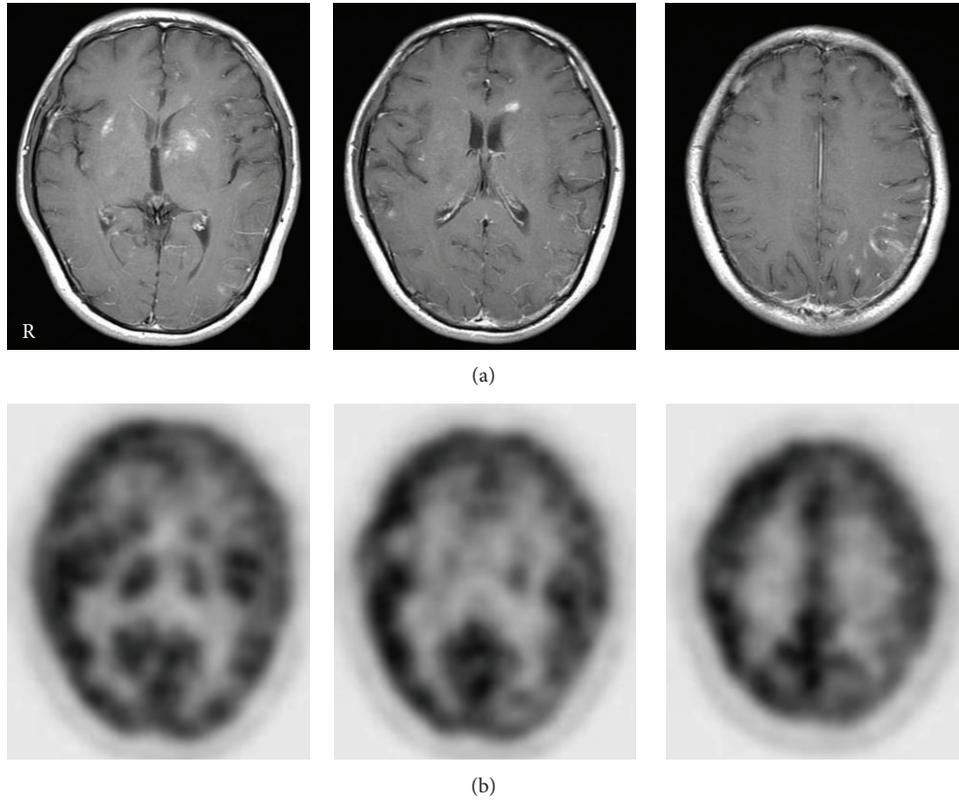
Contrast-enhanced T1-weighted MR (a) and <sup>18</sup>F-FDG PET (b) images in an HIV-positive patient with toxoplasmosis. MR images show multiple, small, irregular enhanced lesions in the basal ganglia and the white matter. PET images show no <sup>18</sup>F-FDG uptake in the lesions.
